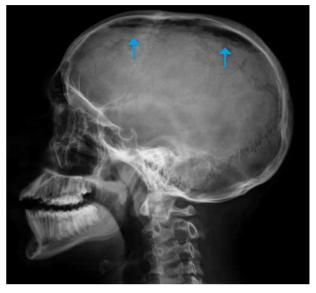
Skull radiography, sagittal plan, showing air inside the intracranial cavity (blue arrows).
